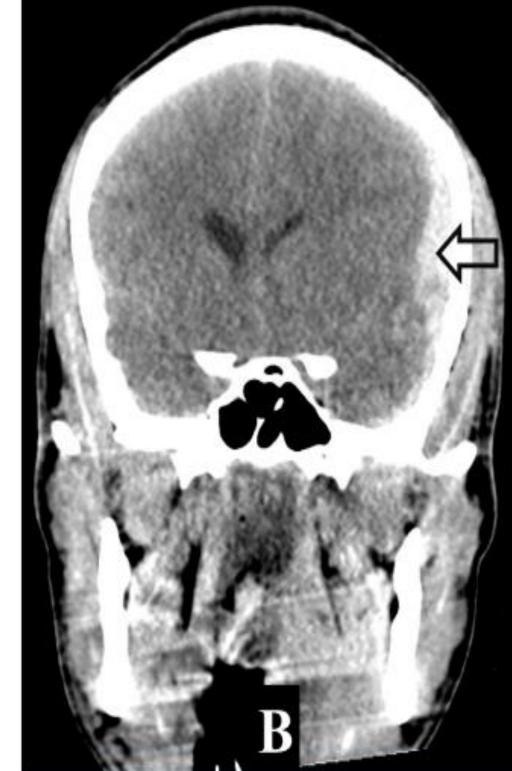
CT scan brain without iv contrast: A) axial and B) coronal cuts showing Left parietal subdural haemorrhage measuring 9 mm in width (black arrow) causing a mass effect with a 4 mm midline shift to the right, subgaleal hematoma with gas foci noted in the right occipito-parietal region of the head (yellow arrow).
